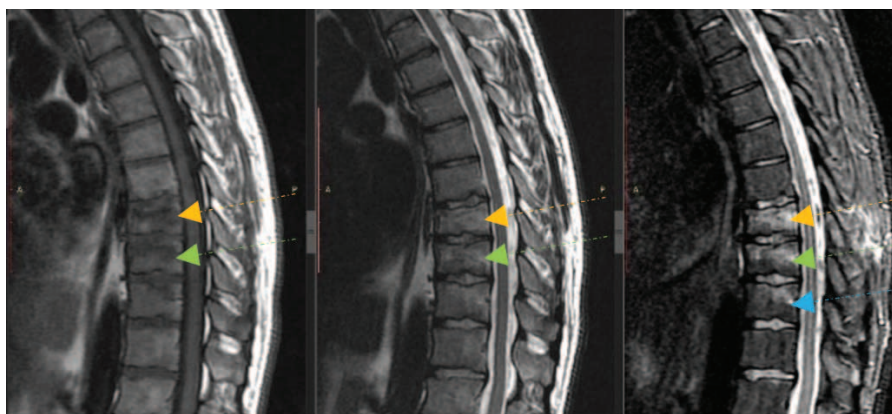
MRI of the thoracic spine: acute compression fracture of the T8 (yellow arrow), T9 (green arrow) vertebrae: decrease in the height of the ventral part of the bodies, wedge-shaped shape of the vertebral bodies, decreased signal intensity in T1 WI, an increased intensity in T2 WI, significantly increased signal intensity in STIR mode from the body as a manifestation of an acute bone edema on the background of a «fresh» fracture. Similar changes in the body of the Th10 vertebra (blue arrow), as a reflection of bone contusion or incipient compression fracture.
